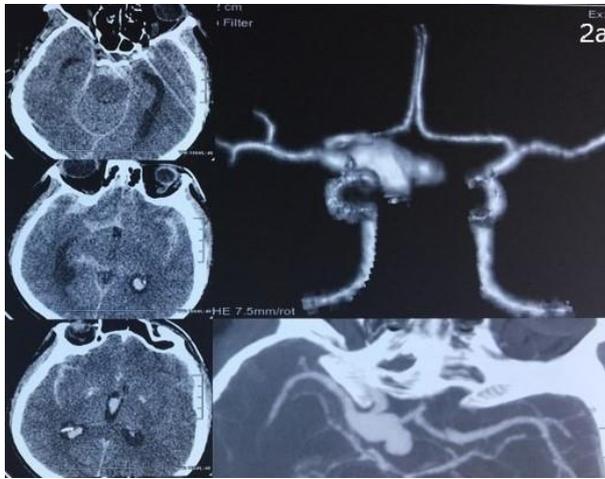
(2a) Preoperative cerebral computed tomography (CT) showed subarachnoid haemorrhage; computed tomography angiography (CTA) demonstrated a large right-sided paraclinoid aneurysm and the relation with the anterior clinoid process; (2b,2c) Preoperative four vessels cerebral angiography showed a 16 mm length right superior hypophyseal artery aneurysm; (2d,2e) Postoperative control cerebral angiography showed the correct obliteration of the aneurysm with a straight 11 Yasargil clip.
